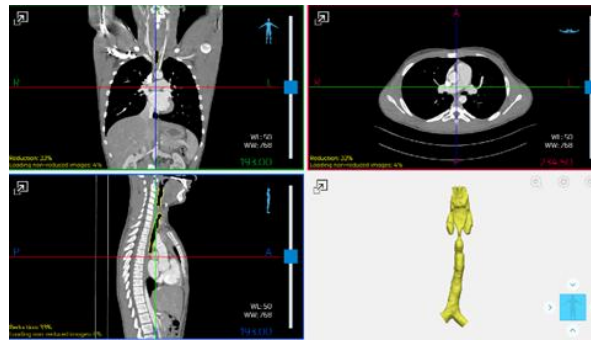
Example of a segmentation of the tracheal anatomy from high-resolution CT scans of a pediatric patient using Materialise Mimics (version 26.0).
